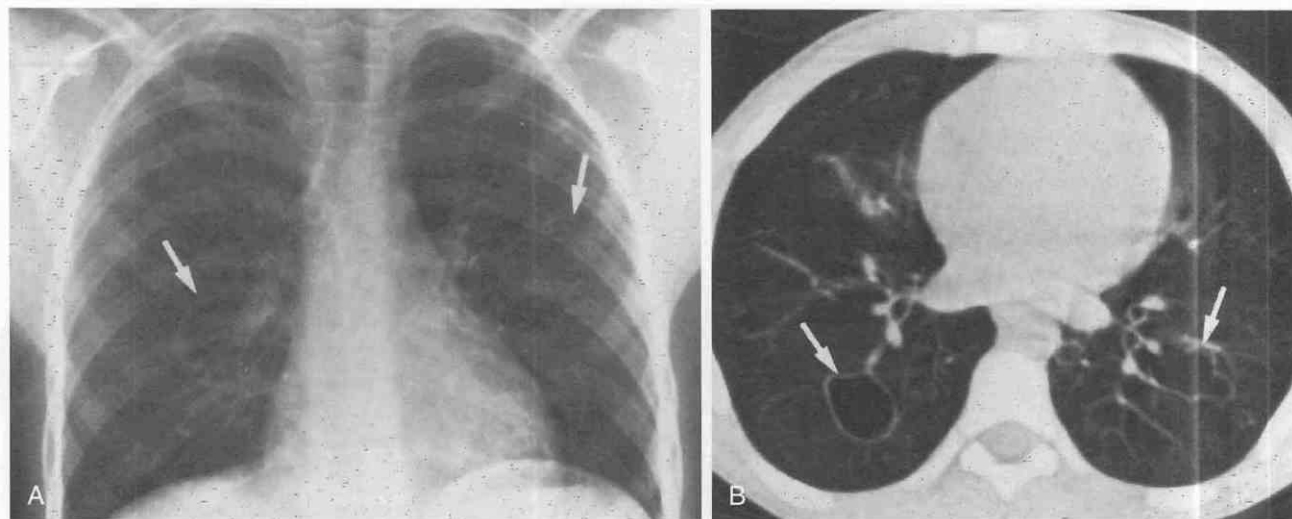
CT features of juvenile tracheolaryngeal papillomatosis. Several thin, delicate-walled cystic air spaces are seen (arrows) on the chest film (A) and the CT scan (B) in this 12-year-old boy with upper airway papillomas. (From Kuhlman JE, Reyes BL, Hruban RH, et al: Abnormal air-filled spaces in the lung. *Radiographics* 13:47-75, 1993.)
